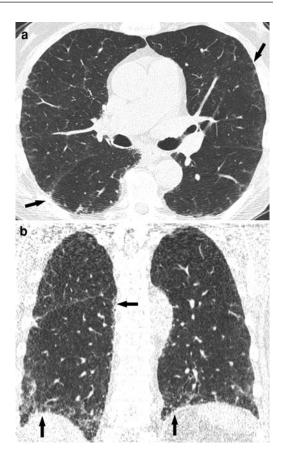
Usual interstitial pneumonia. Transverse (a) and coronal reformatted (b) low-dose HRCT images show subpleural and basal reticulation (*arrows*)
